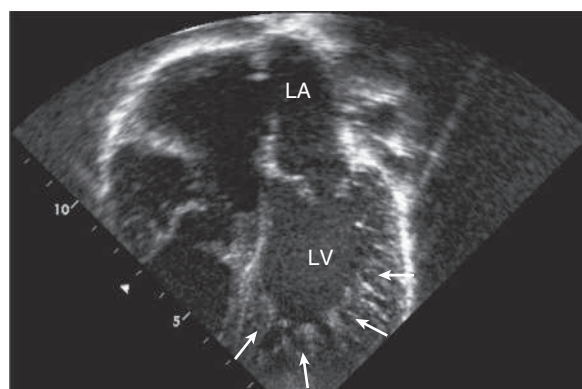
Echocardiogram of a patient with left ventricular noncompaction cardiomyopathy. Apical view showing abnormal trabeculations of left ventricle at the apex (arrows). For comparison, see the smooth-walled LV in [Figure 488.2](#). LA, Left atrium; LV, left ventricle.
